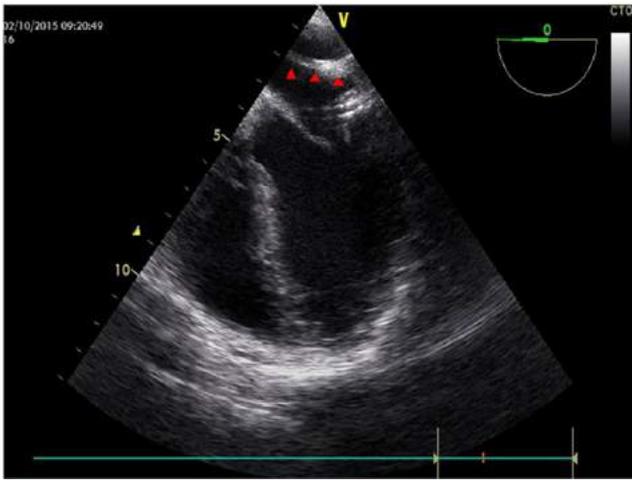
Transesophageal echocardiogram demonstrating left atrial band extending from interatrial septum to the lateral wall of the left atrium (arrowheads).
